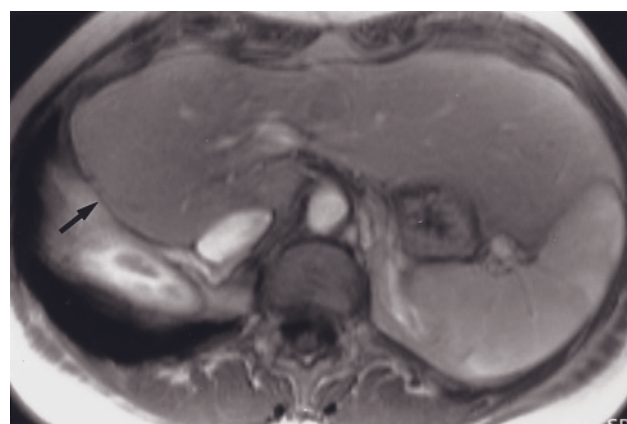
Before and after liver resection. T2-weighted SS-ETSE (*a*, *e*), SGE (*b*), and immediate (*c*, *f*) and 90-s fat-suppressed (*d*, *g*) postgadolinium SGE images. The images before resection (*a*–*d*) show a 9-cm HCC in the right hepatic lobe. After resection, a small biloma is present (arrow, *f*). Note the heterogeneous mildly increased enhancement along the resection margin on early-phase images (*f*) that fades on late-phase images (*g*), features of early granulation tissue and mild inflammation.
